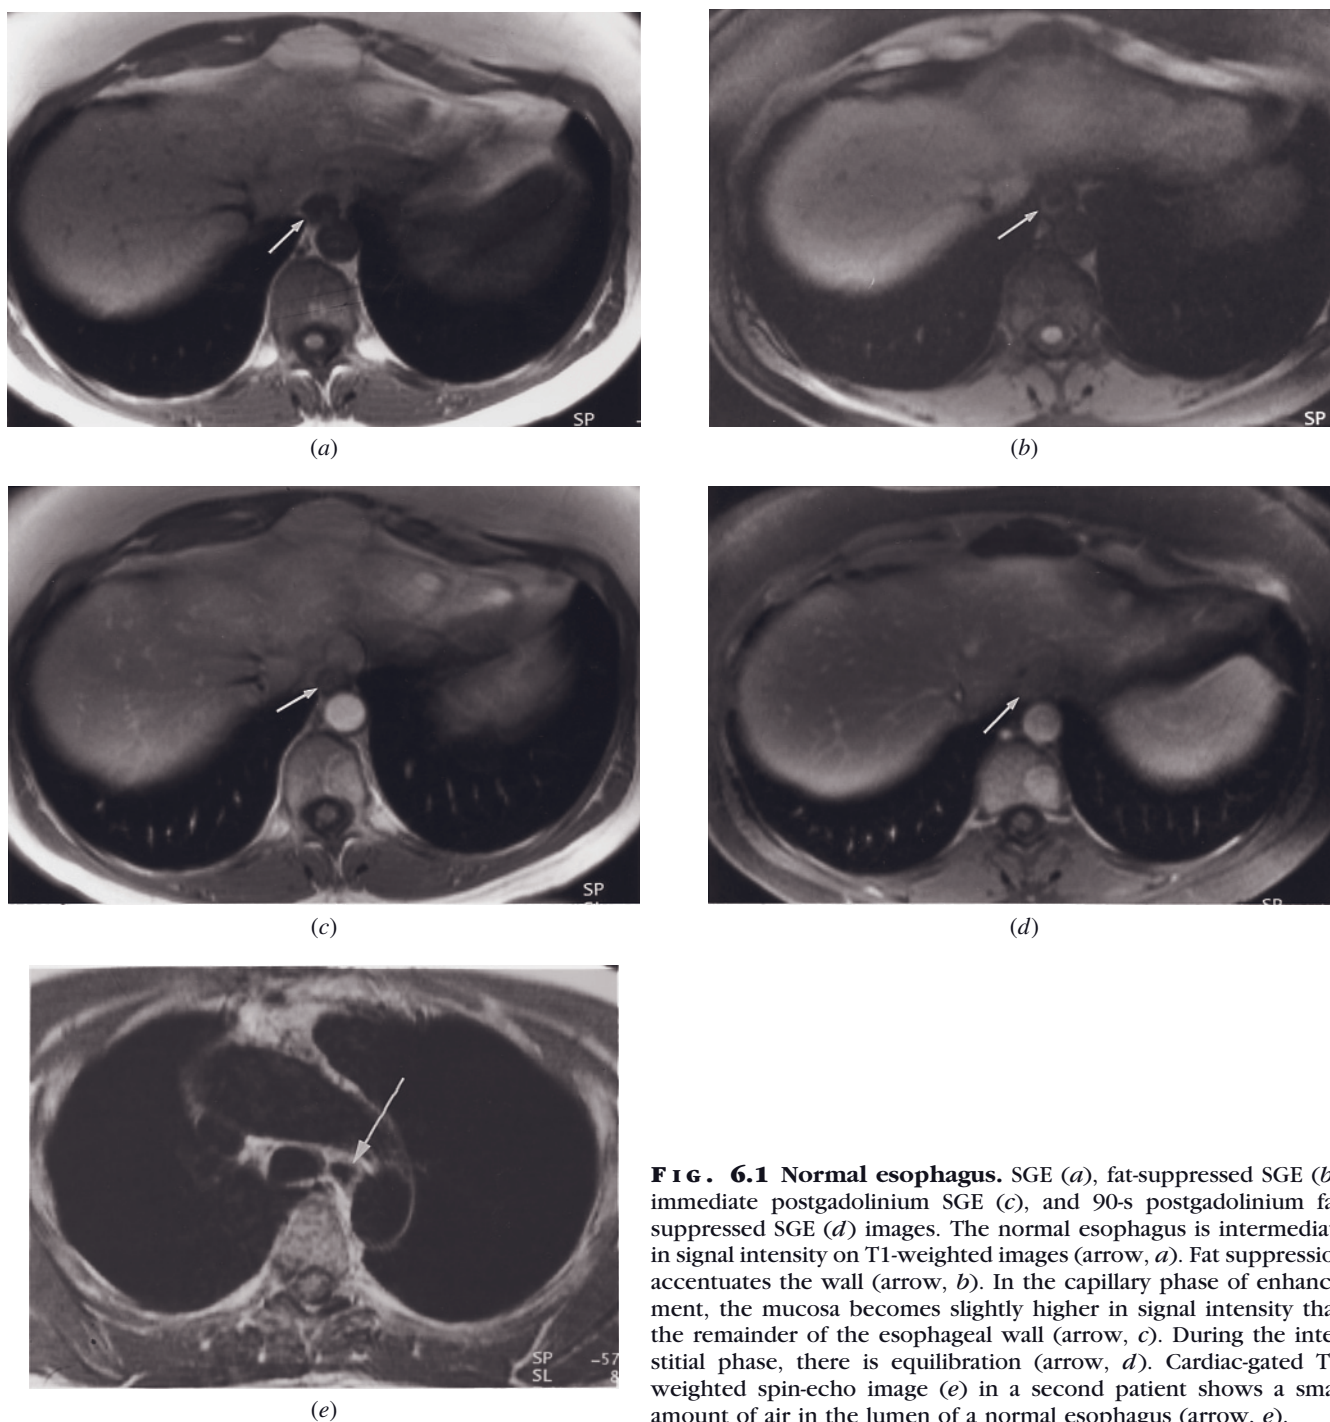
Normal esophagus. SGE (*a*), fat-suppressed SGE (*b*), immediate postgadolinium SGE (*c*), and 90-s postgadolinium fat-suppressed SGE (*d*) images. The normal esophagus is intermediate in signal intensity on T1-weighted images (arrow, *a*). Fat suppression accentuates the wall (arrow, *b*). In the capillary phase of enhancement, the mucosa becomes slightly higher in signal intensity than the remainder of the esophageal wall (arrow, *c*). During the interstitial phase, there is equilibration (arrow, *d*). Cardiac-gated T1-weighted spin-echo image (*e*) in a second patient shows a small amount of air in the lumen of a normal esophagus (arrow, *e*).
